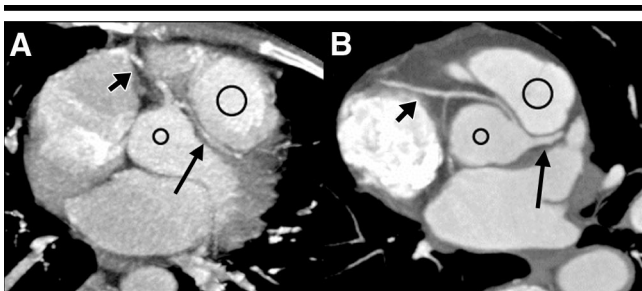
Anomalous coronary arteries at four-detector row CT. Thin oblique transverse maximum intensity projections in two patients with intermittent chest discomfort demonstrate anomalous origin and course of a major coronary artery between aortic root (small circles) and outflow tract of the right ventricle (large circles), resulting in compression and distortion of the artery. *A*, Anomalous LAD coronary artery (large arrow) has a common origin with the dominant right coronary artery (small arrow) from the right coronary sinus of Valsalva. *B*, Anomalous right coronary artery (small arrow) originates directly from the left coronary sinus of Valsalva, separately from the left coronary artery system (large arrow).
